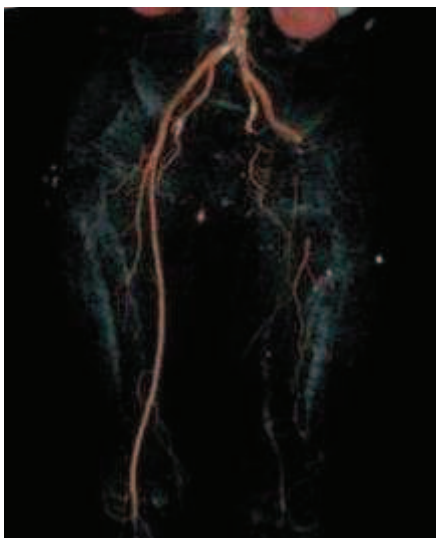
A CT angiogram showing complete obstruction of the left femoral artery. Calcifications and thrombi can be seen in the aorta and common iliac arteries.
